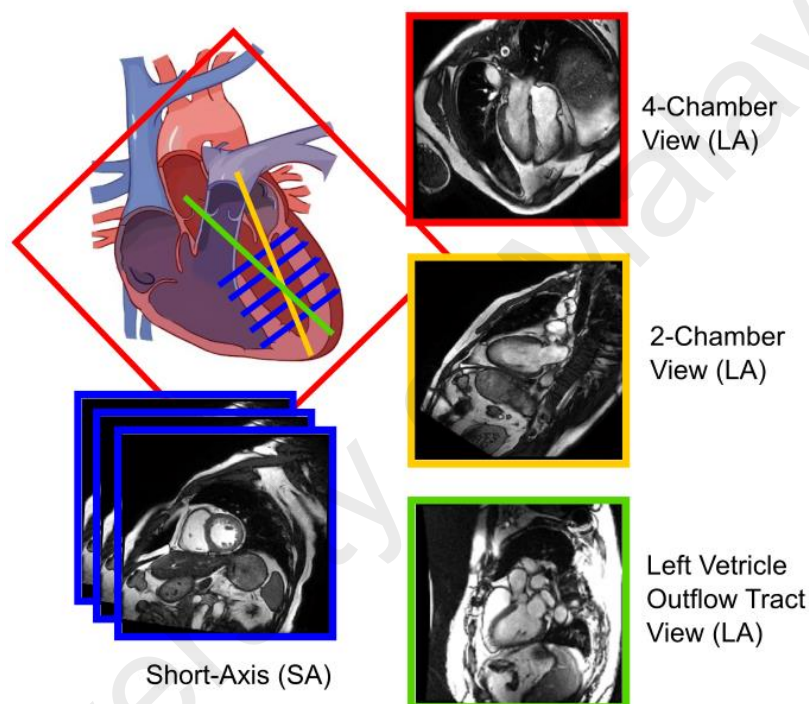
Conventional cardiac MRI acquisition views of the LV. (Red) 4-chamber LA view aligned with all four chambers of the heart through the mitral and tricuspid valves. (Yellow) 2-chamber view vertically cutting through the apex and center of mitral valve. (Greenland et al.) LV outflow tract view aligned through the LV and the centers of the mitral and aortic valves. (Blue) SA image stacks across the LV from base to apex.
